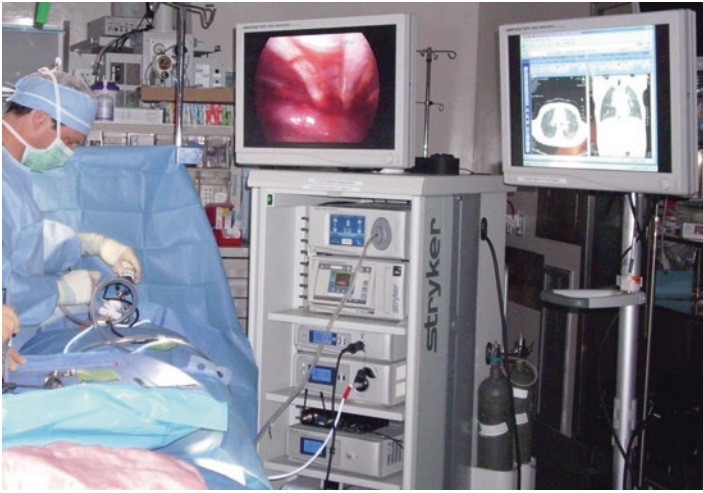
This setup allows the surgeon to view both the thoracoscopic image and the computed tomography scan simultaneously facilitated with exact localization of the target lesion.
